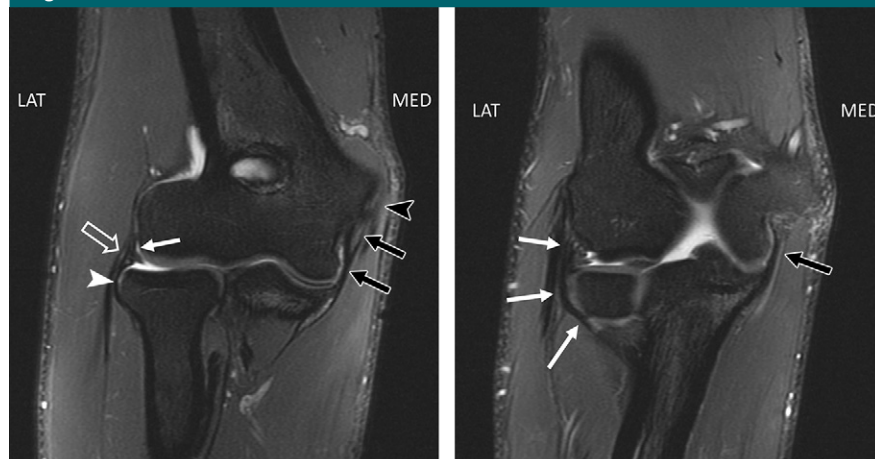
(a) Coronal T2-weighted fat-saturated (FS) MR image through the elbow demonstrates the UCL (black arrows) and overlying common flexor tendon (black arrowhead) on the medial side (*MED*). On the lateral side (*LAT*) is the radial collateral ligament with an adjacent synovial fold (white arrow), the annular ligament (white arrowhead), and the overlying extensor carpi radialis brevis origin (open arrow). (b) Coronal T2-weighted FS MR image through the elbow demonstrates the posterior band of the UCL (black arrow) on the medial side and LUCL (white arrows) on the lateral side.
